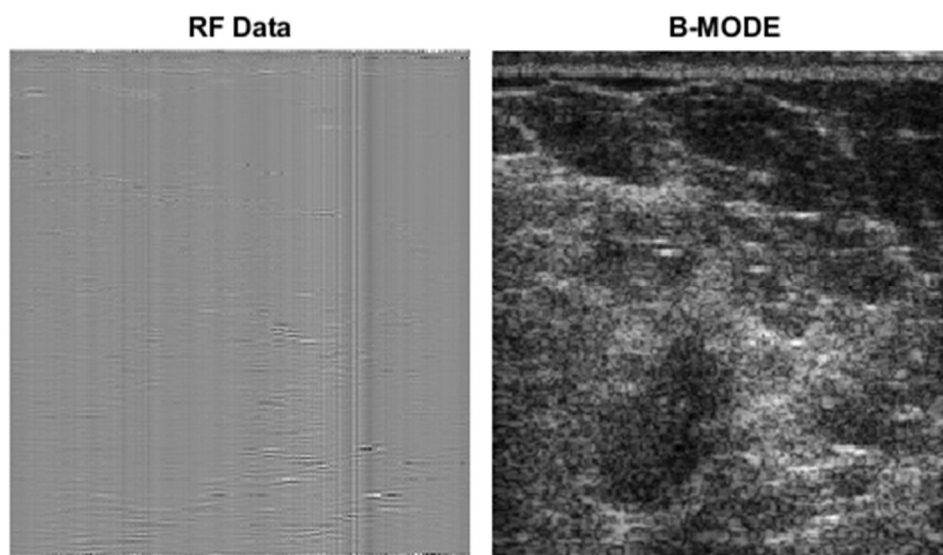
Sample RF data image acquired from a breast cancer case along with corresponding B-Mode ultrasound image .
